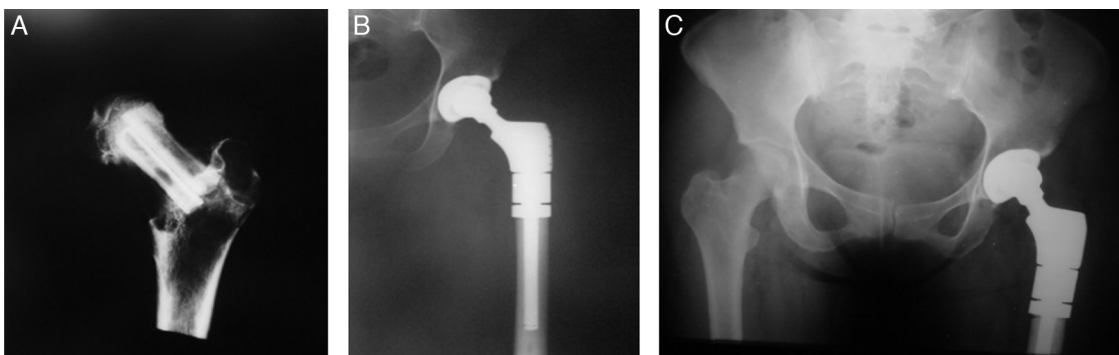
Left hip radiographs in anteroposterior view, showing the section with safety margin (A), and the endoprosthesis for the proximal femur (B and C).
